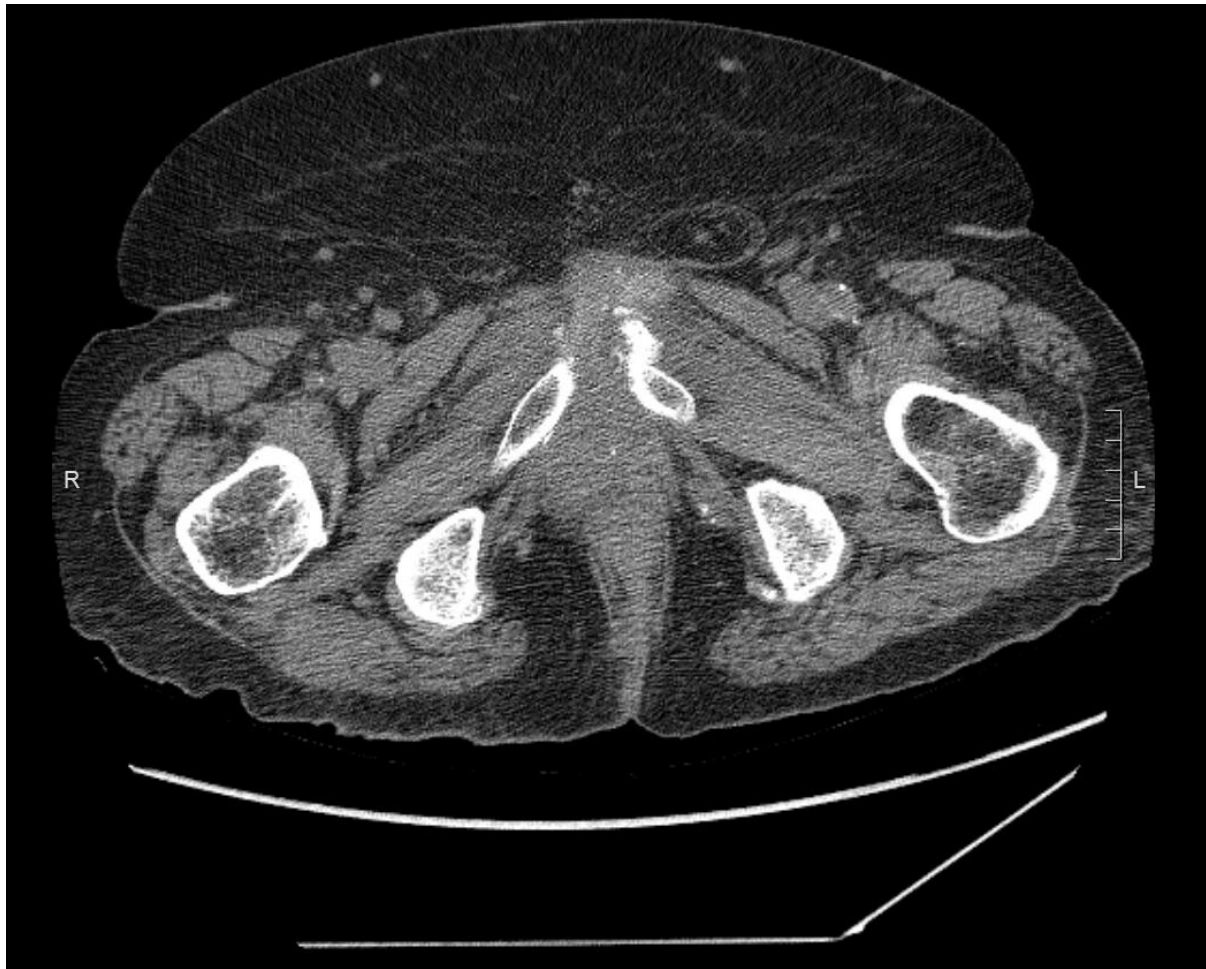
T2-weighted magnetic resonance imaging demonstrating the widened pubic symphysis as well as contrast extravasation from the anterior margin of urethra suggestive of leak.
